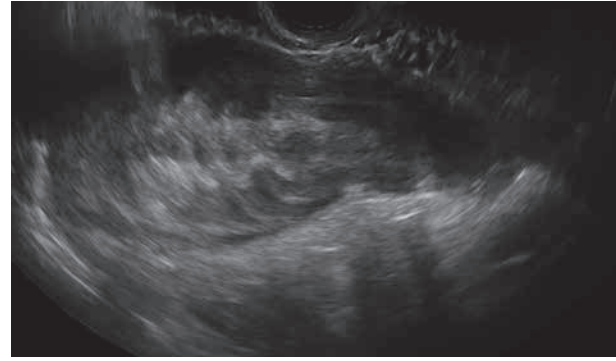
Diagnosis through ultrasonography after CT scan. Whipped cream characteristic.
